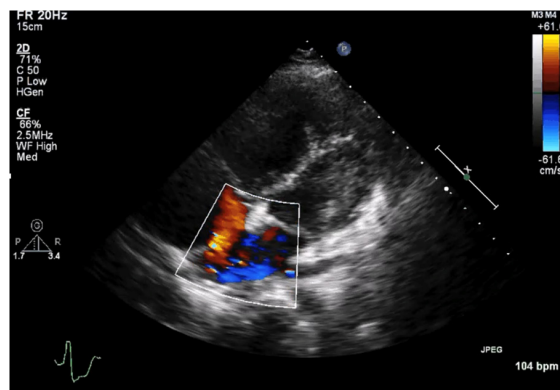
Color doppler echocardiography demonstrated secundum atrial septum defect.
